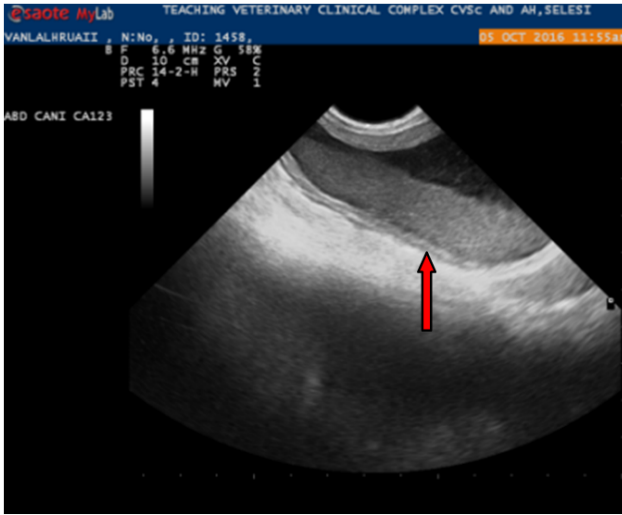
Ultrasonography of urinary bladder revealed diffused hyperechoic wall thickening ($\geq 8\text{mm}$) with hyperechoic mucosal interface and an irregularly shaped echogenic mass within the anechoic lumen indicating severe cystitis
